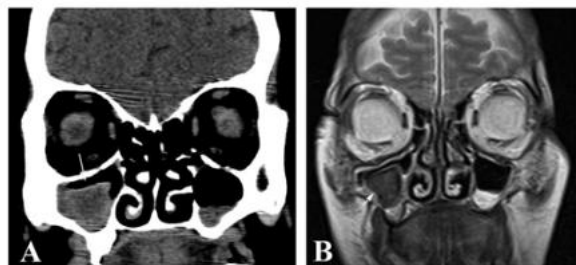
Imaging features of fungal ball (fungal mycetoma). (A) Coronal CT image of the paranasal sinuses demonstrates a focal hyperattenuating mass within the maxillary sinus (arrow), with associated mucosal thickening. The sinus walls are preserved, with no evidence of bony erosion or extra sinus extension, favoring a non-invasive fungal process. (B) Coronal T2-weighted MRI shows a markedly hypointense lesion within the involved maxillary sinus (arrow), characteristic of dense fungal concretions due to the presence of paramagnetic elements. The surrounding sinus mucosa shows mild inflammatory changes, consistent with a fungal ball.
